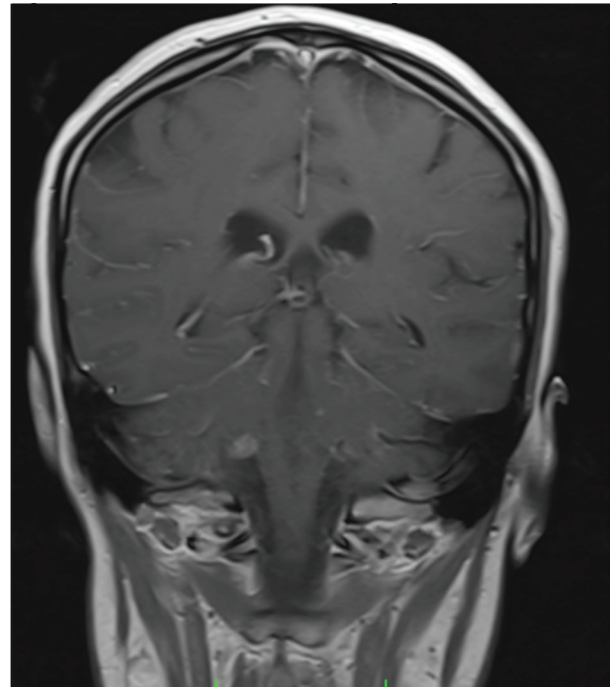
Contrast-enhanced brain MRI of the patient
